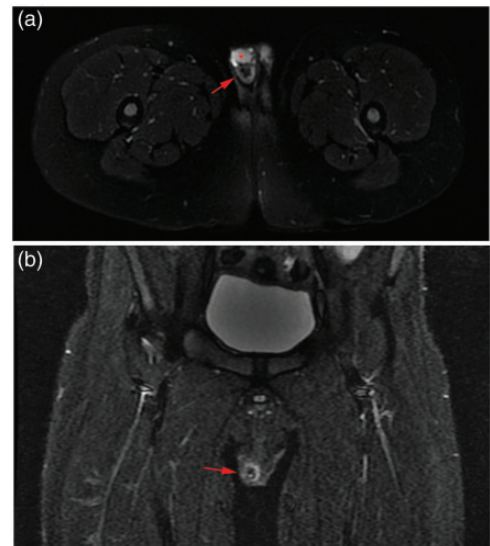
Magnetic resonance imaging of the scrotum. Images show well-defined masses (red arrows) separate from the testis (red asterisk).
